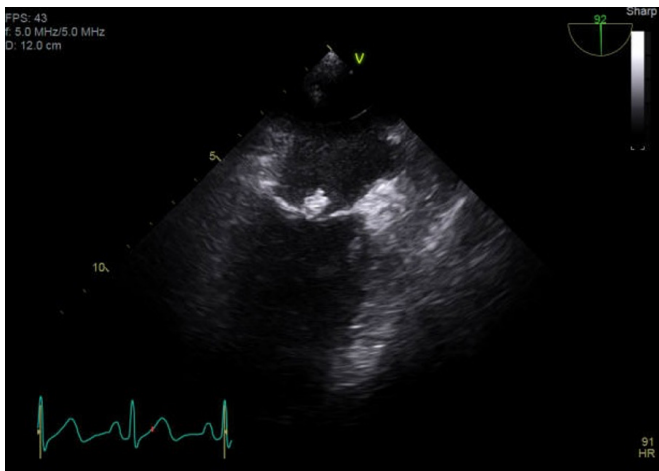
Transoesophageal echocardiogram revealing a large posterior mitral valve leaflet vegetation.
